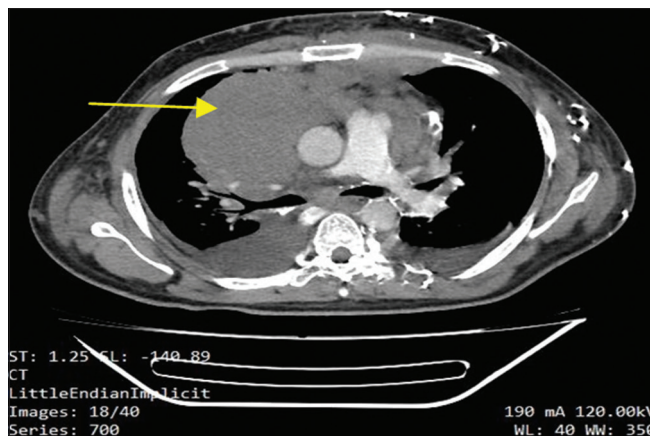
CECT study confirmed bilateral pleural effusion with soft tissue mass in the mediastinum. CECT: Contrast-enhanced computed tomography
